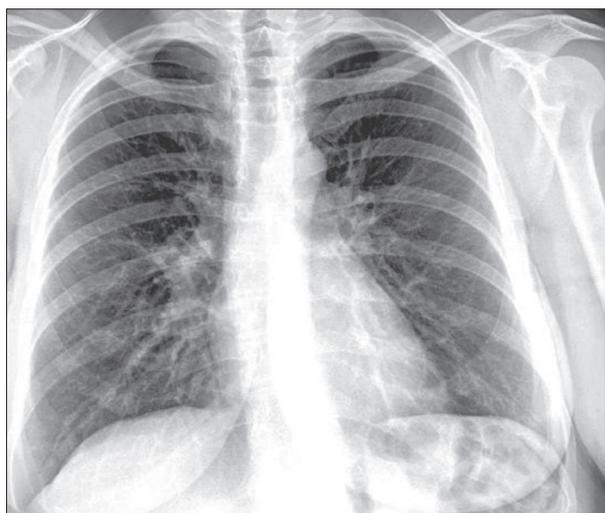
Chest X-ray on admission, with signs of diffuse bronchovascular markings
